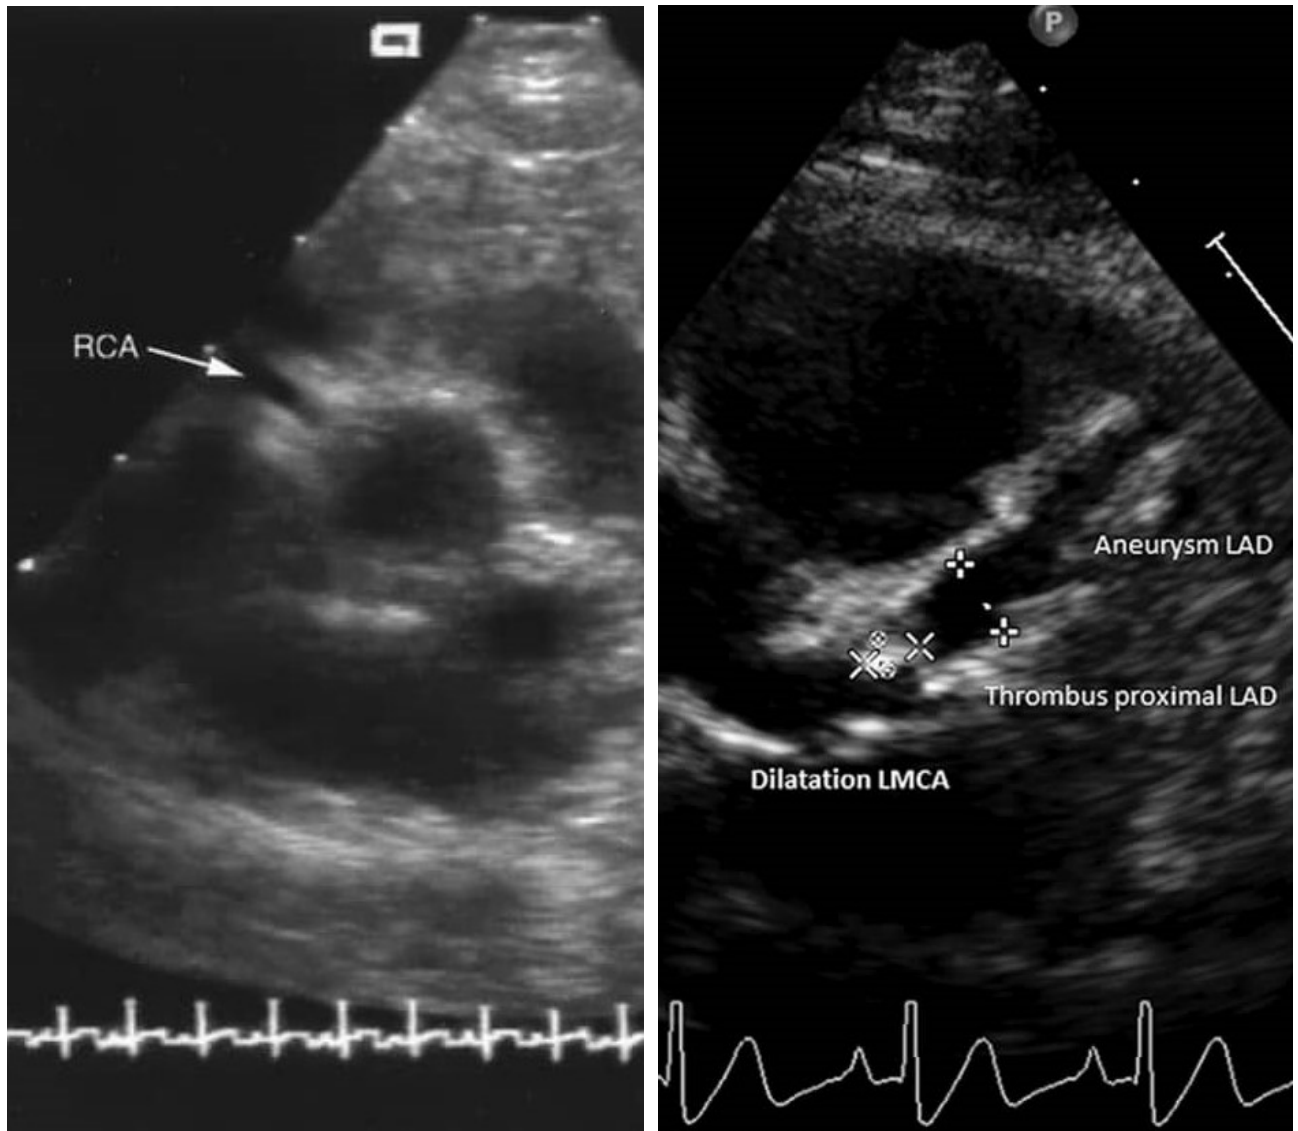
Echocardiography for sizing coronary artery. Internal diameter is measured.
